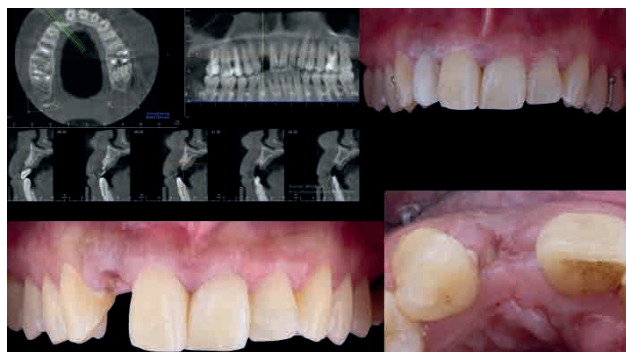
Pre-surgical CBCT image and removable acrylic provisional prosthesis. The lower images show healing at 2 weeks following alveolar preservation (xenograft + L-PRF).
